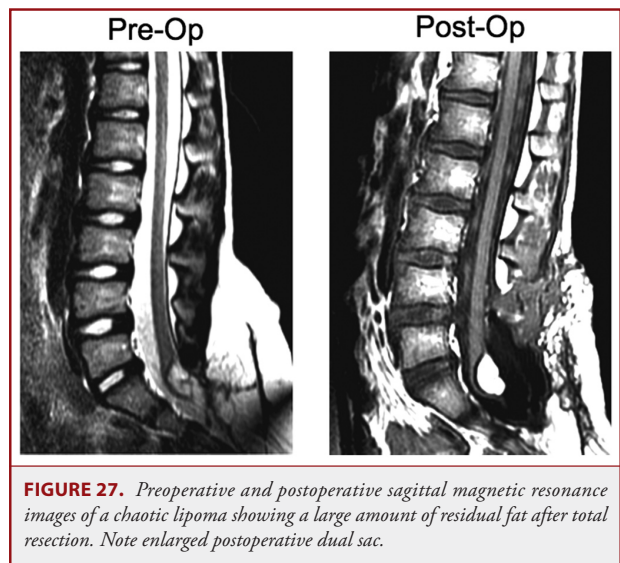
Preoperative and postoperative sagittal magnetic resonance images of a chaotic lipoma showing a large amount of residual fat after total resection. Note enlarged postoperative dual sac.
